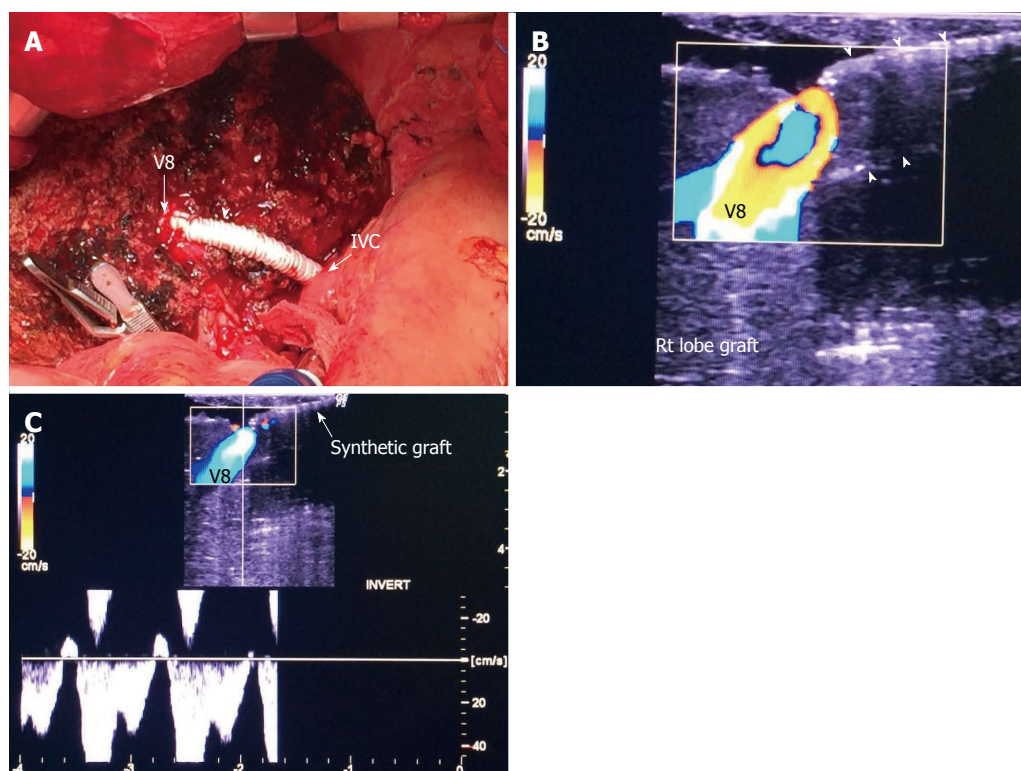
Intra-operative ultrasound evaluation of segment VIII synthetic graft. A: Photography showing the synthetic graft (arrow head) between V8 and IVC; B: Color image showing patent segment VIII vein and absence of color flow in the synthetic graft (arrow heads); C: Color Doppler image showing normal triphasic waveform in segment VIII vein, confirming synthetic graft patency. V8: Segment VIII hepatic vein; IVC: Inferior vena cava.
